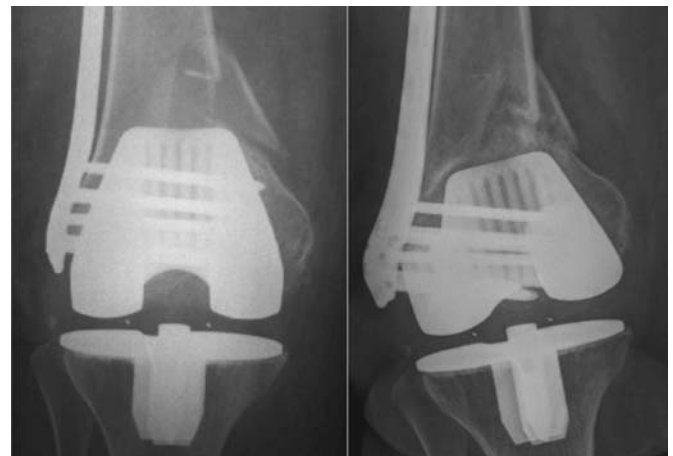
Periprosthetic distal femur fracture of an 80-year-old patient after low energy trauma. Postoperative x-ray in ap-view after angular stable plate fixation (left) and 3-month postoperative follow-up showing the varus-failure with screw “cut-out” into the knee joint (right).
